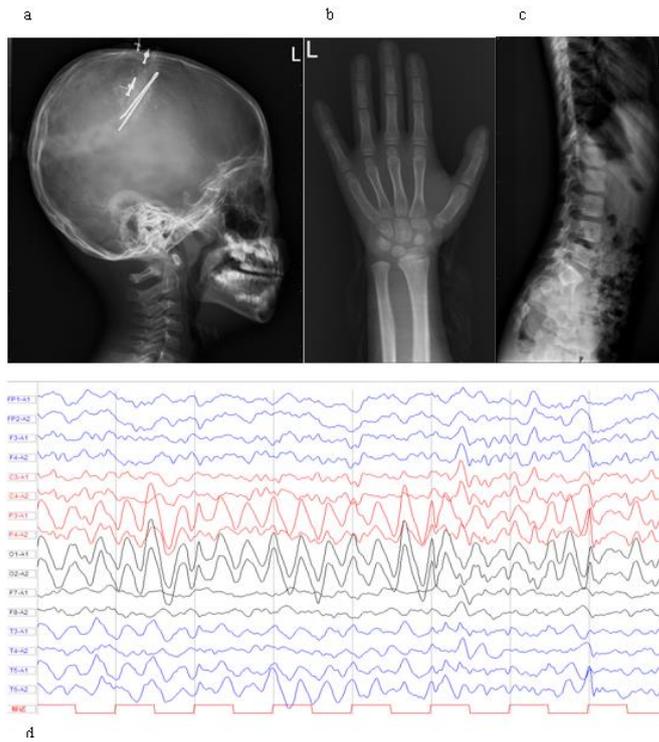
Skeletal radiographs and EEG of the present case at 5.8 y. (a) Lateral skull radiograph. (b) Left hand radiograph. (c) Lateral vertebrae radiograph. (d) EEG.
